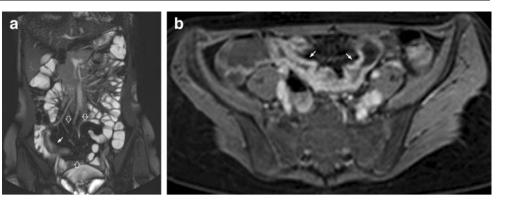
A 15-year-old child with CD. MRI. a Coronal balanced fast-field-echo image shows thickening of the terminal ileum (*arrow*) and fibrofatty proliferation (*white open arrows*).
